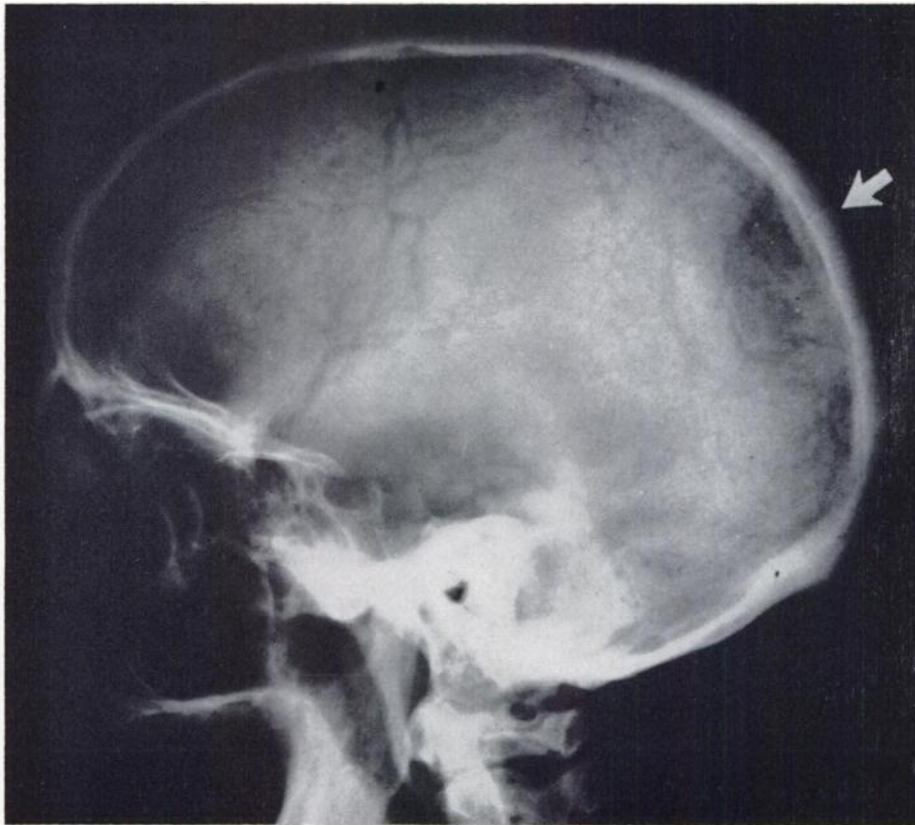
Skull film of 57 year old male who noted a mass in left occipital area. Biopsy revealed a meningioma, and roentgenogram (above) showed typical but minimal changes characteristic of this tumor (arrow).
